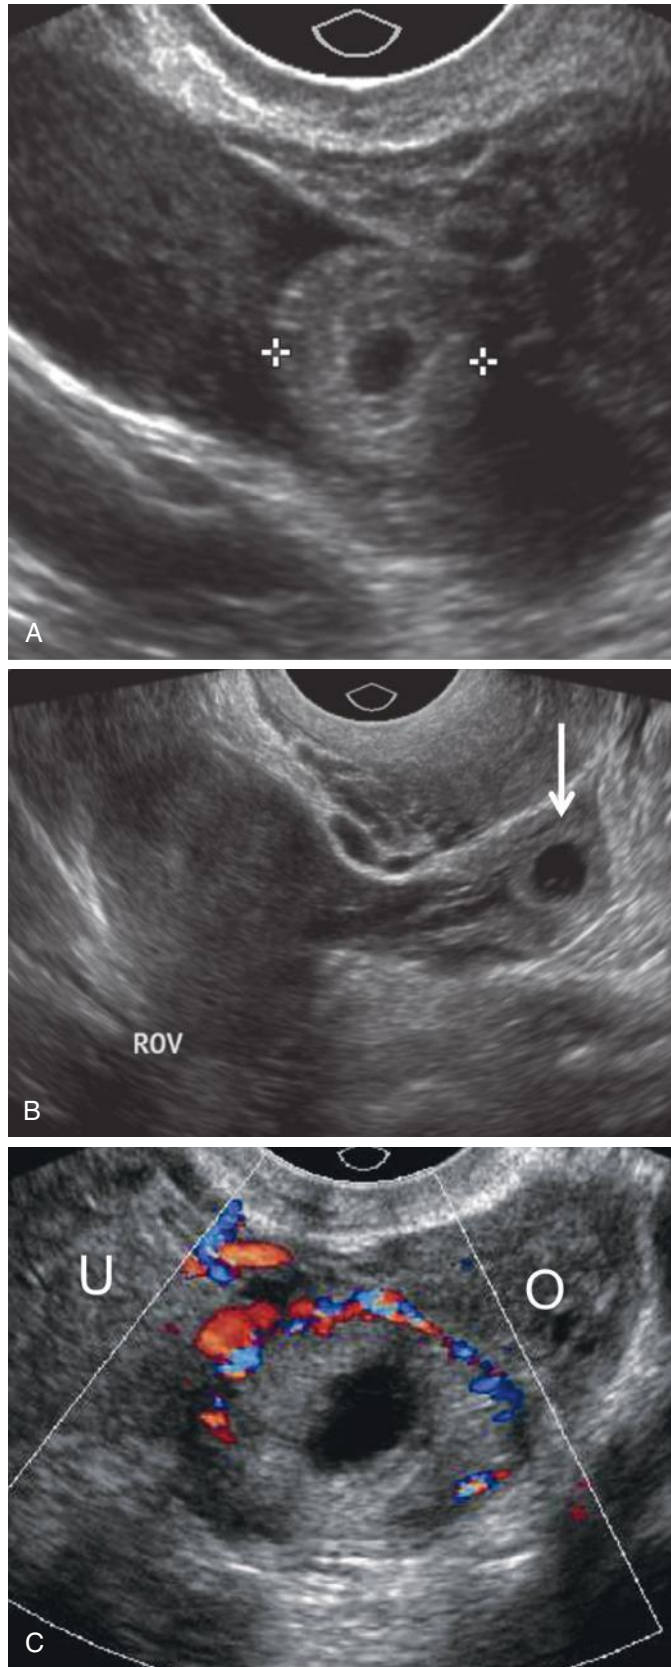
Ectopic pregnancies presenting as tubal rings in three different patients. A, Transvaginal scan shows a typical adnexal tubal ring (*between calipers*), also called a “sugar donut” or “bagel” sign, representing an empty ectopic gestational sac with a round anechoic fluid-filled center surrounded by a thick echogenic rim. Note a small amount of adjacent free pelvic fluid. B, Transvaginal scan shows the small tubal ring of an ectopic pregnancy (*arrow*) separate from and medial to the right ovary (ROV). C, Transvaginal transverse color Doppler scan shows the tubal ring of an ectopic pregnancy located between the uterus (U) and left ovary (O). Note the incomplete color Doppler “ring of fire.”
